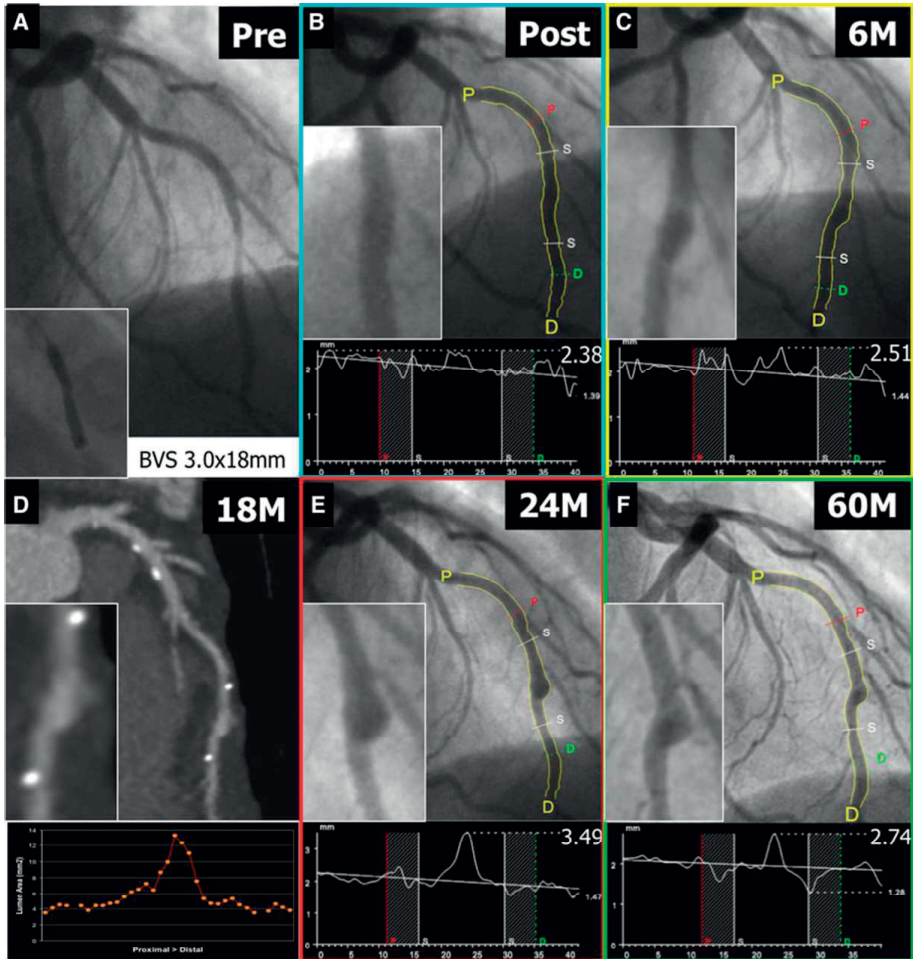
Coronary angiography of the left anterior descending artery before (A) and after (B) intervention at baseline. At 6 months, the planned angiography showed an ectasia in the scaffolded segment (C). The planned multislice computed tomography showed lumen dilatation in the scaffolded segment at 18 months (D). Repeat angiography demonstrated that the ectatic lesion in the scaffold became aneurysmal at 2 years (E) and diminished at 5 years (F).
